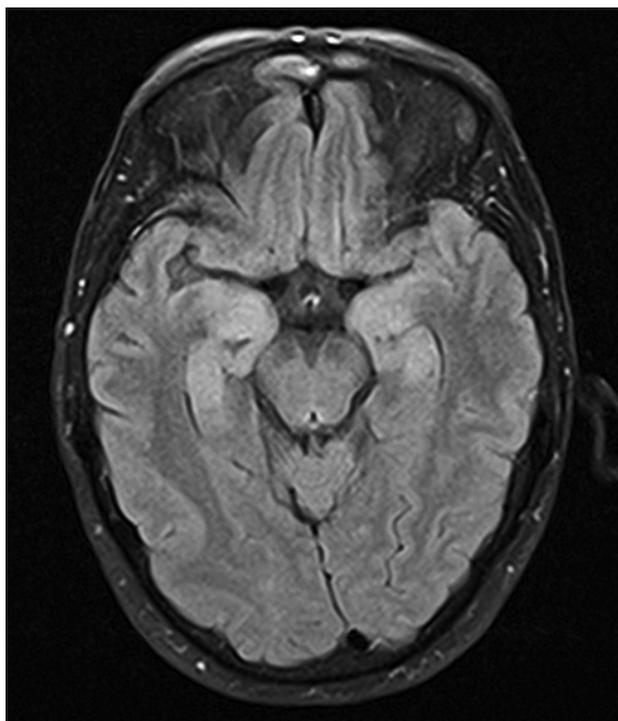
Brain MRI scan (T2 FLAIR sequence) of the patient performed on October 8, 2020
